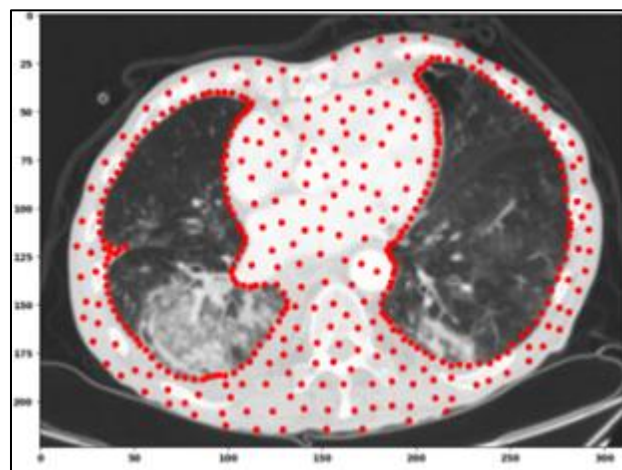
The red dots around the lung of the sample CT scan refers 391 points selected
